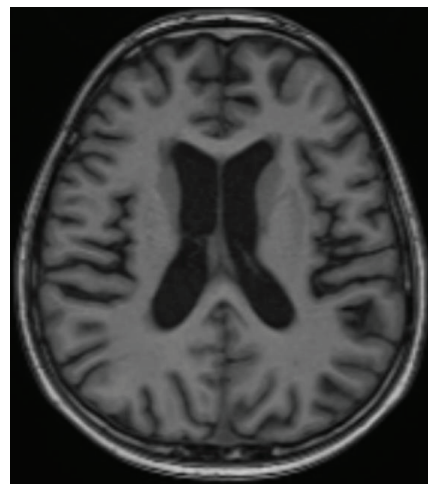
MRI with complete resolution of the parietal and frontal cortical-subcortical lesions described in the previous CT scan, attributable to recovered Posterior Reversible Encephalopathy Syndrome (PRES).
